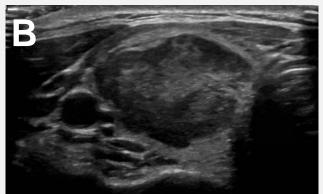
Long-axis (A) and short-axis (B) ultrasonographic appearance of right thyroid nodule measuring $3.9 \times 2.0 \times 3.1$ cm and demonstrating irregular contours and heterogeneity of the nodule.
